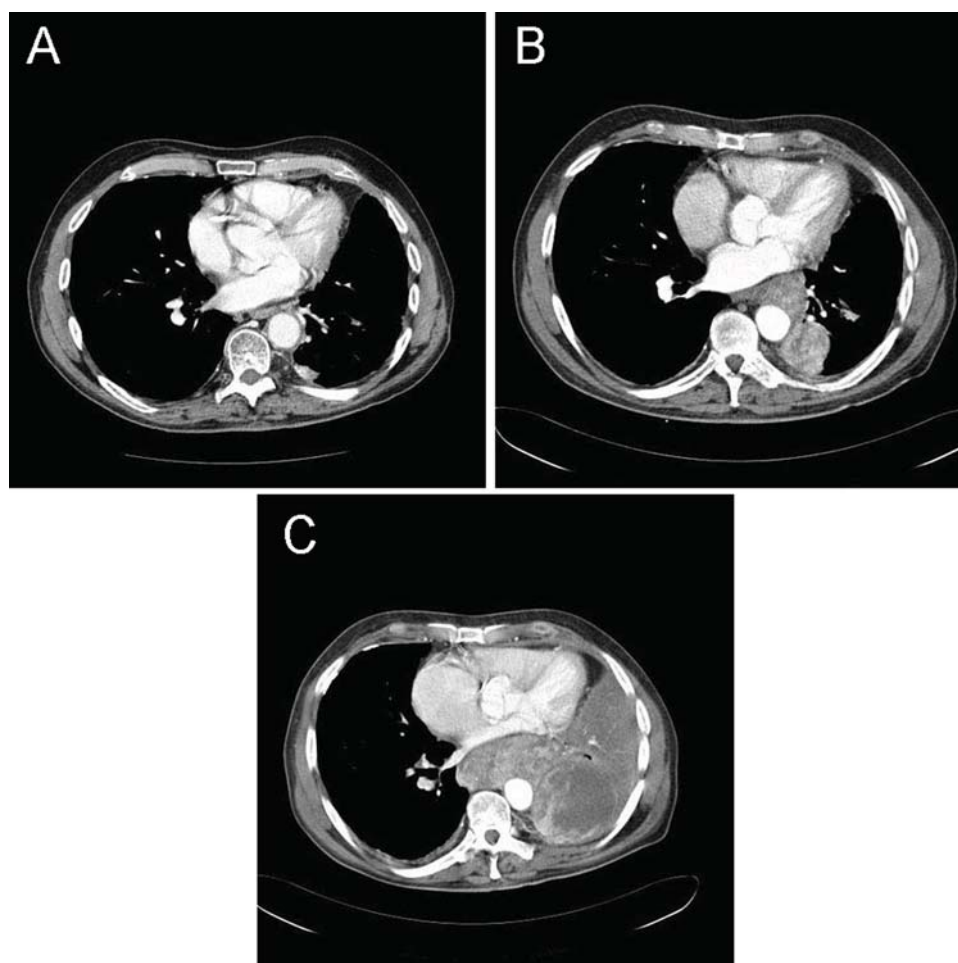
(A) CT of the thorax – initial diagnostic CT performed 15 months prior to presentation in the emergency department. (B) Recurrent disease 4 months prior to presentation in the emergency department. (C) Aggressive mesothelioma with infiltration of the pericardium and collapse of the left lung. There is impingement of the left atrium.
